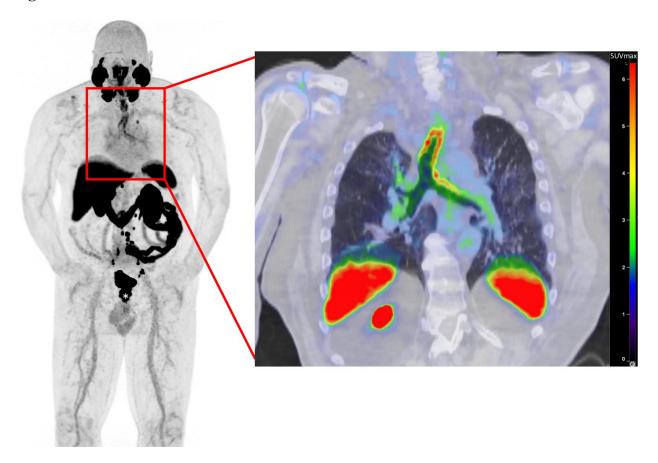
F-18 piflufolastat prostate specific membrane antigen positron emission tomography / computed tomography highlighting increased uptake throughout the large airways.
